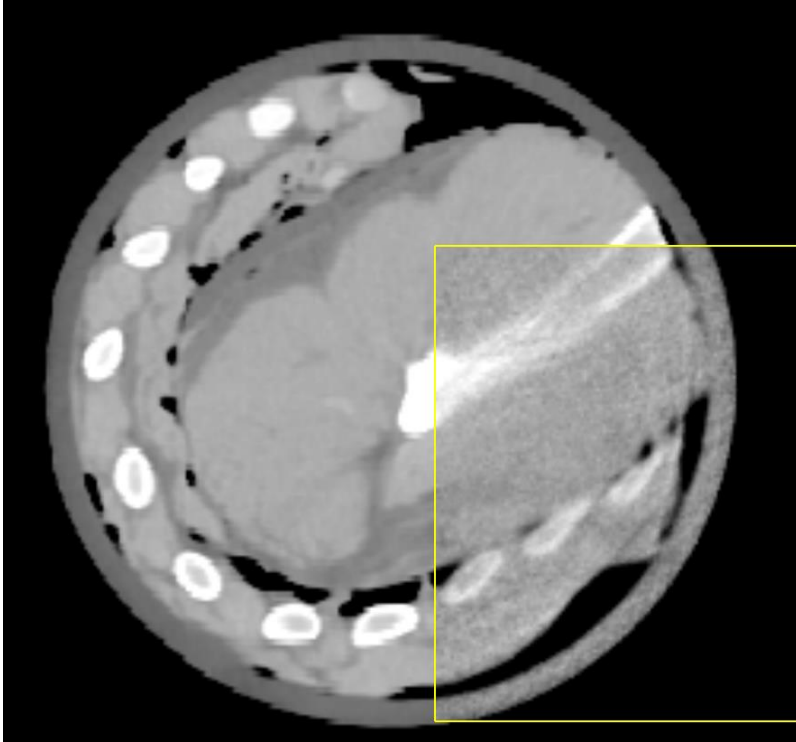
Pork tissue axial image on a CT slice with high-Z material.
